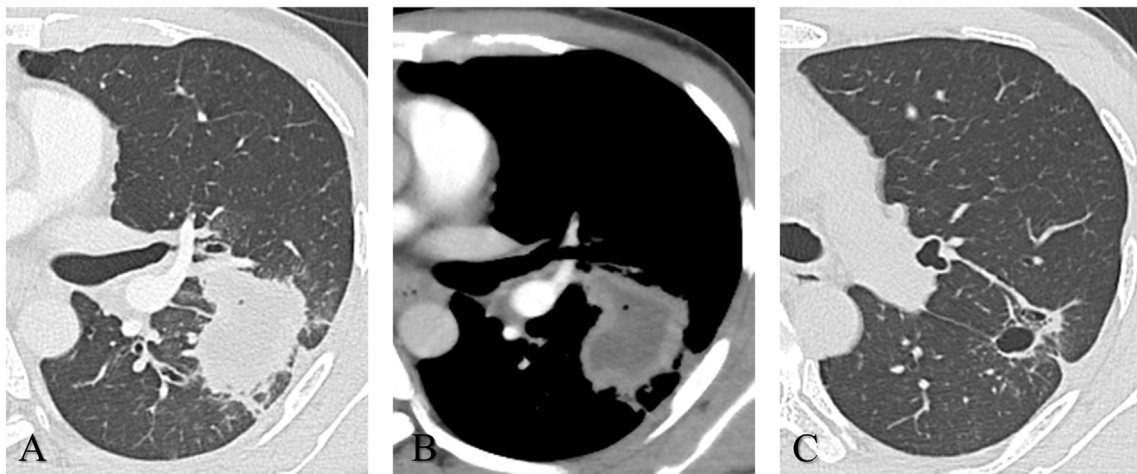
(A/B) Chest computed tomography on transfer to our hospital showed low attenuation within consolidation in the left lung, which was crossing a fissure. (C) After the patient received antibiotic therapy for two months, his abnormal lung shadow showed apparent improvement.
